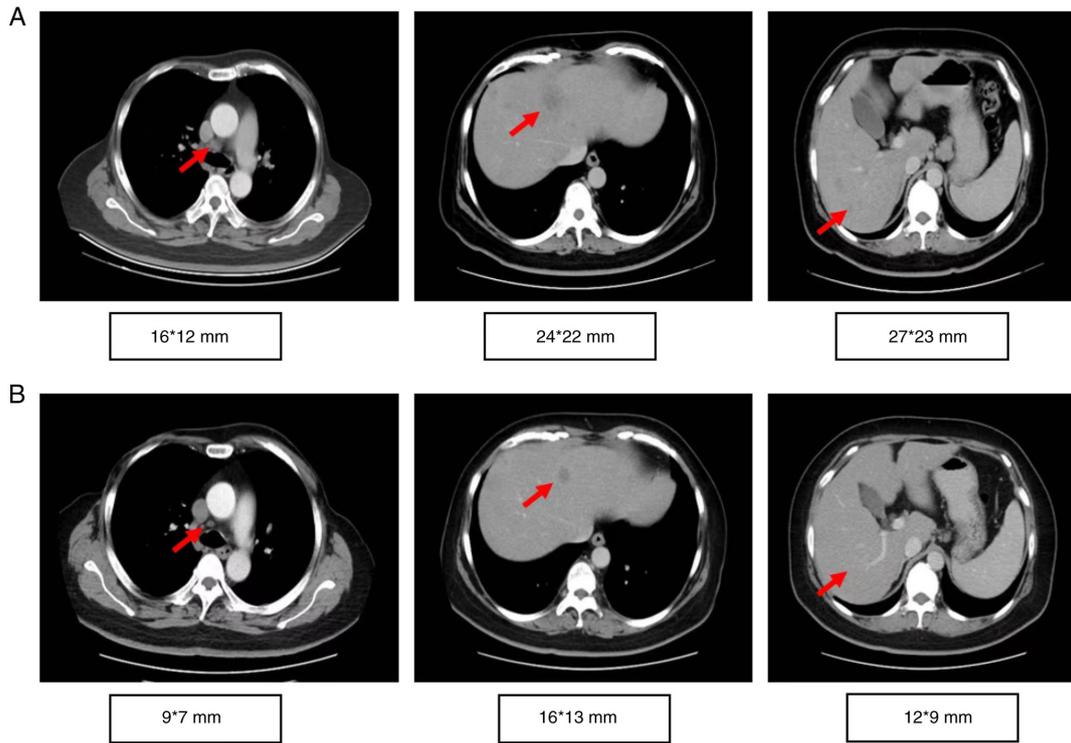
Computed tomography scan results before and after treatment. Computed tomography scan of the chest and abdomen (A) before initiation (December 2018) and (B) after six months of olaparib therapy (June 2019). Arrows state metastatic lesions.
